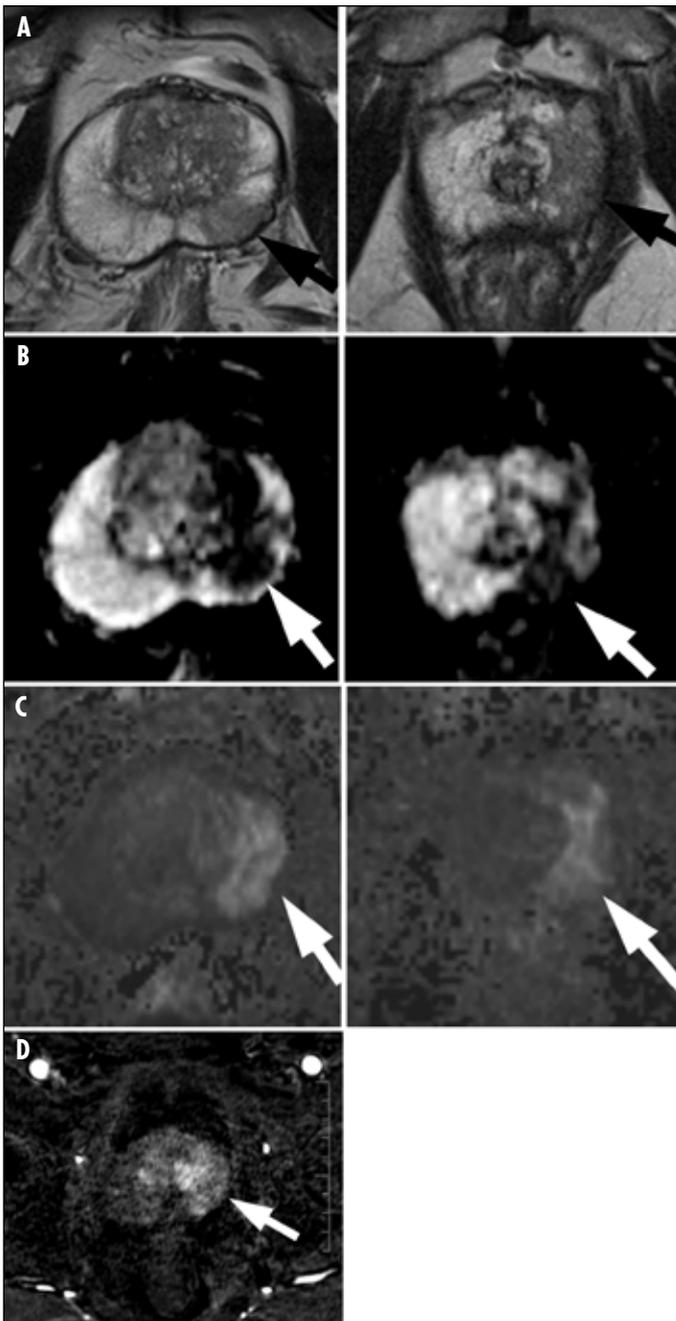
Multiparametric magnetic resonance (MR) imaging findings of foamy prostatic intraepithelial neoplasia. (A, B) Axial T2-weighted fast spin-echo MR image (TR/TE, 4140/97). (C, D) Corresponding axial apparent diffusion coefficient (ADC) map (TR/TE, 4800/70; b values 100, 400, 800, 1000 mm²/s²).
